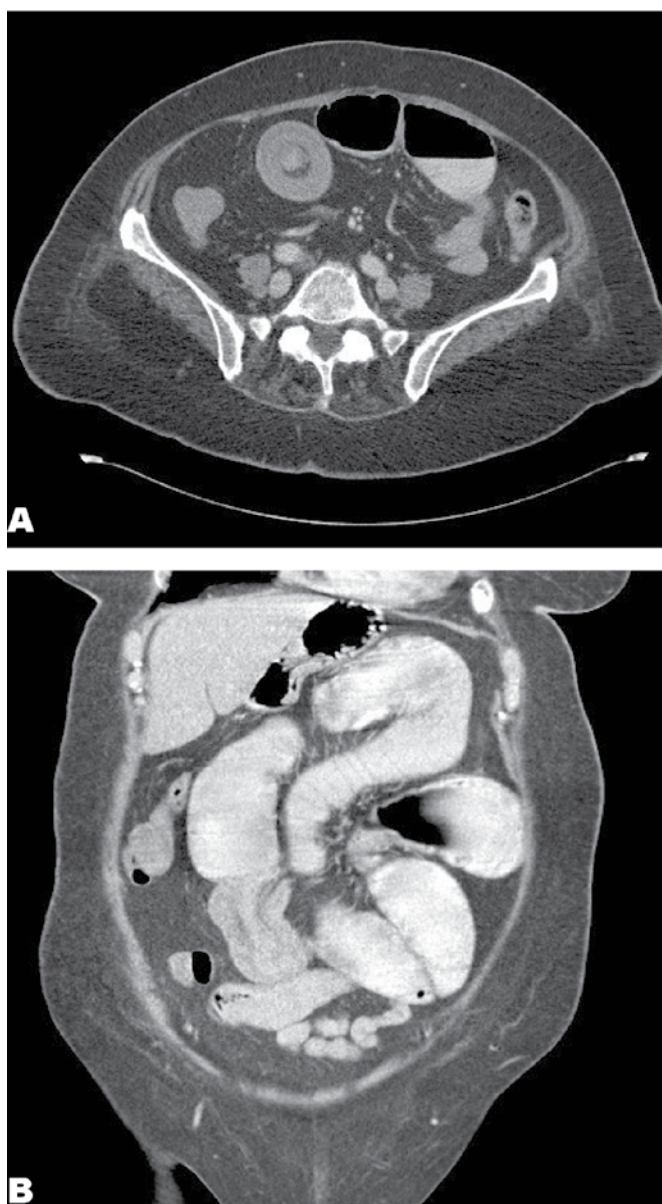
(A) Transverse image from computed tomography scan showing classical target lesion of bowel intussusception (with oral contrast), (B) Coronal image from computed tomography scan showing intussusception of proximal bowel in the distal segment (with oral contrast).
